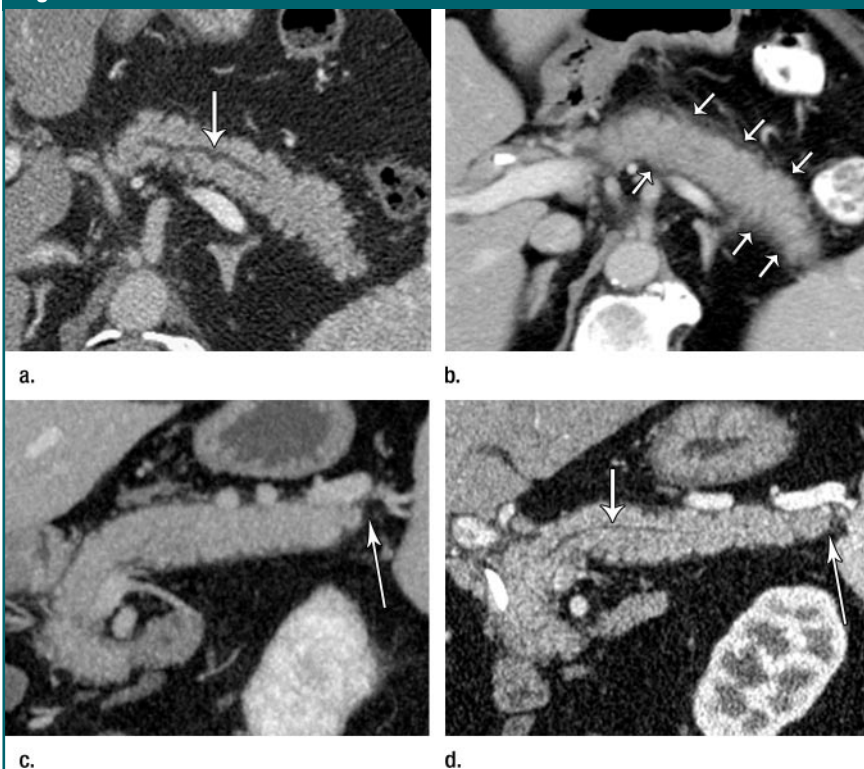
Serial contrast-enhanced CT images through pancreas in 84-year-old woman who presented with abdominal pain, jaundice, and weight loss and had complete response to CST. (a) Axial image from initial examination reveals normal pancreas morphology but minimal prominence of PD (arrow). (b) Axial and (c) coronal images from subsequent study performed at 2-month interval shows diffuse pancreatic swelling with loss of lobularity and a subtle halo around the pancreas (arrows in b). The PD is now attenuated (not visualized), and the pancreatic tail appears foreshortened (arrow in c). (d) Coronal image obtained after 2 months of CST reveals near complete resolution of pancreatic swelling and peripancreatic changes. Note that parenchymal lobularity has reappeared and that the PD (short arrow) is now visualized. Additionally, recovery of the pancreatic tail (long arrow) is observed.
